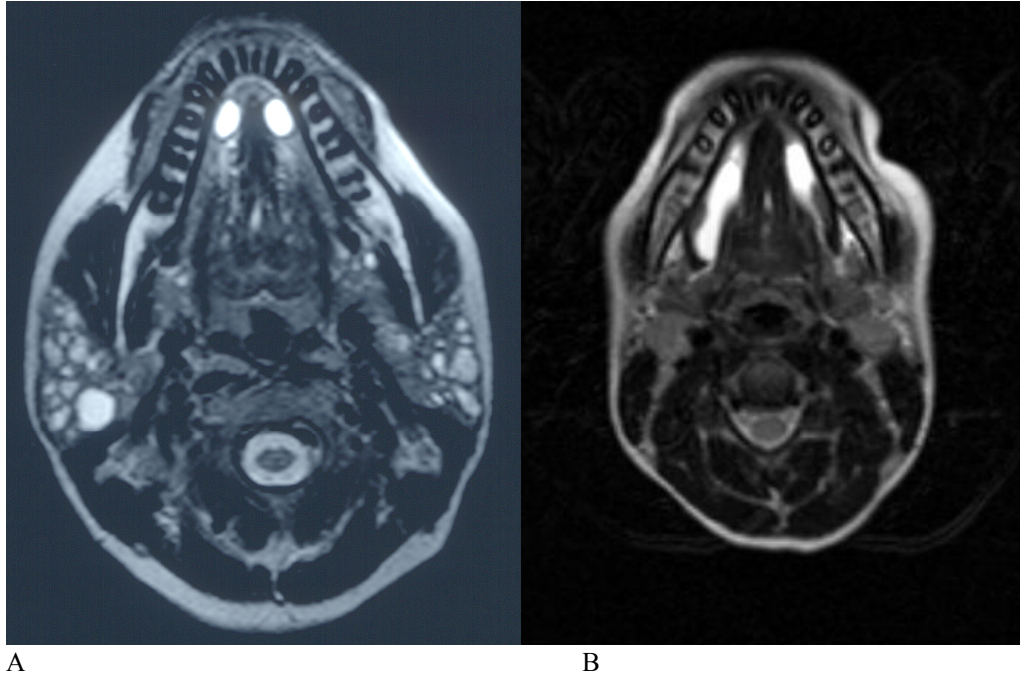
MRI imaging (axial view) of multiple lymphoid infiltrations with bilateral ranulas and HIV-related parotid cysts (1A), and bilateral plunging ranulas (1B).
